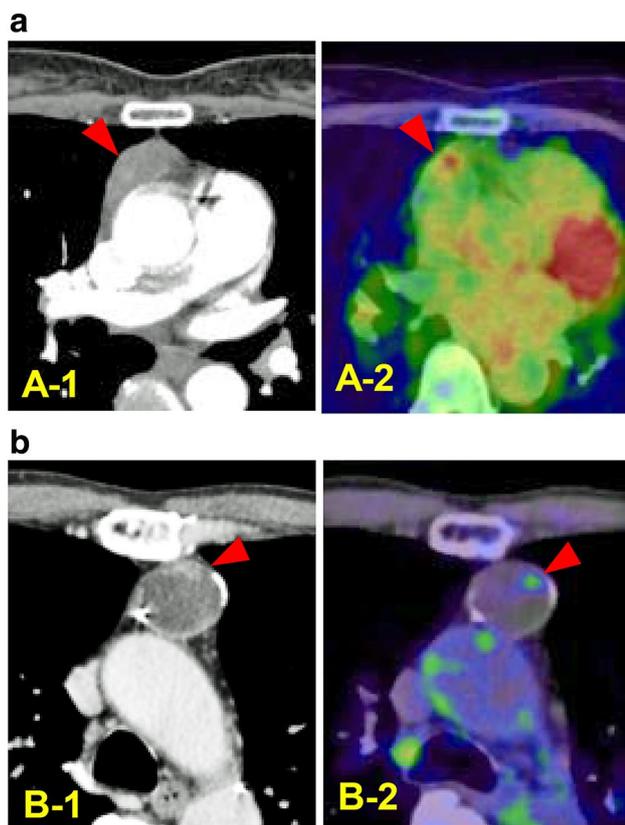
Non-TETs. a Contrast-enhanced CT showed that an oval nodule was an enhanced solid lesion monotonously (A-1), and PET-CT revealed the intermediate accumulation of FDG in the nodule (A-2). Thymoma was suspected based on these radiographic findings. However, a pathological examination showed that it was a MALT lymphoma. b CT showed an oval cystic nodule that had a partially thickened wall (B-1), and PET-CT revealed the slight accumulation of FDG in the wall (B-2). Cystic thymoma was suspected based on these radiographic findings. However, a pathological examination showed that it was a thymic cyst
